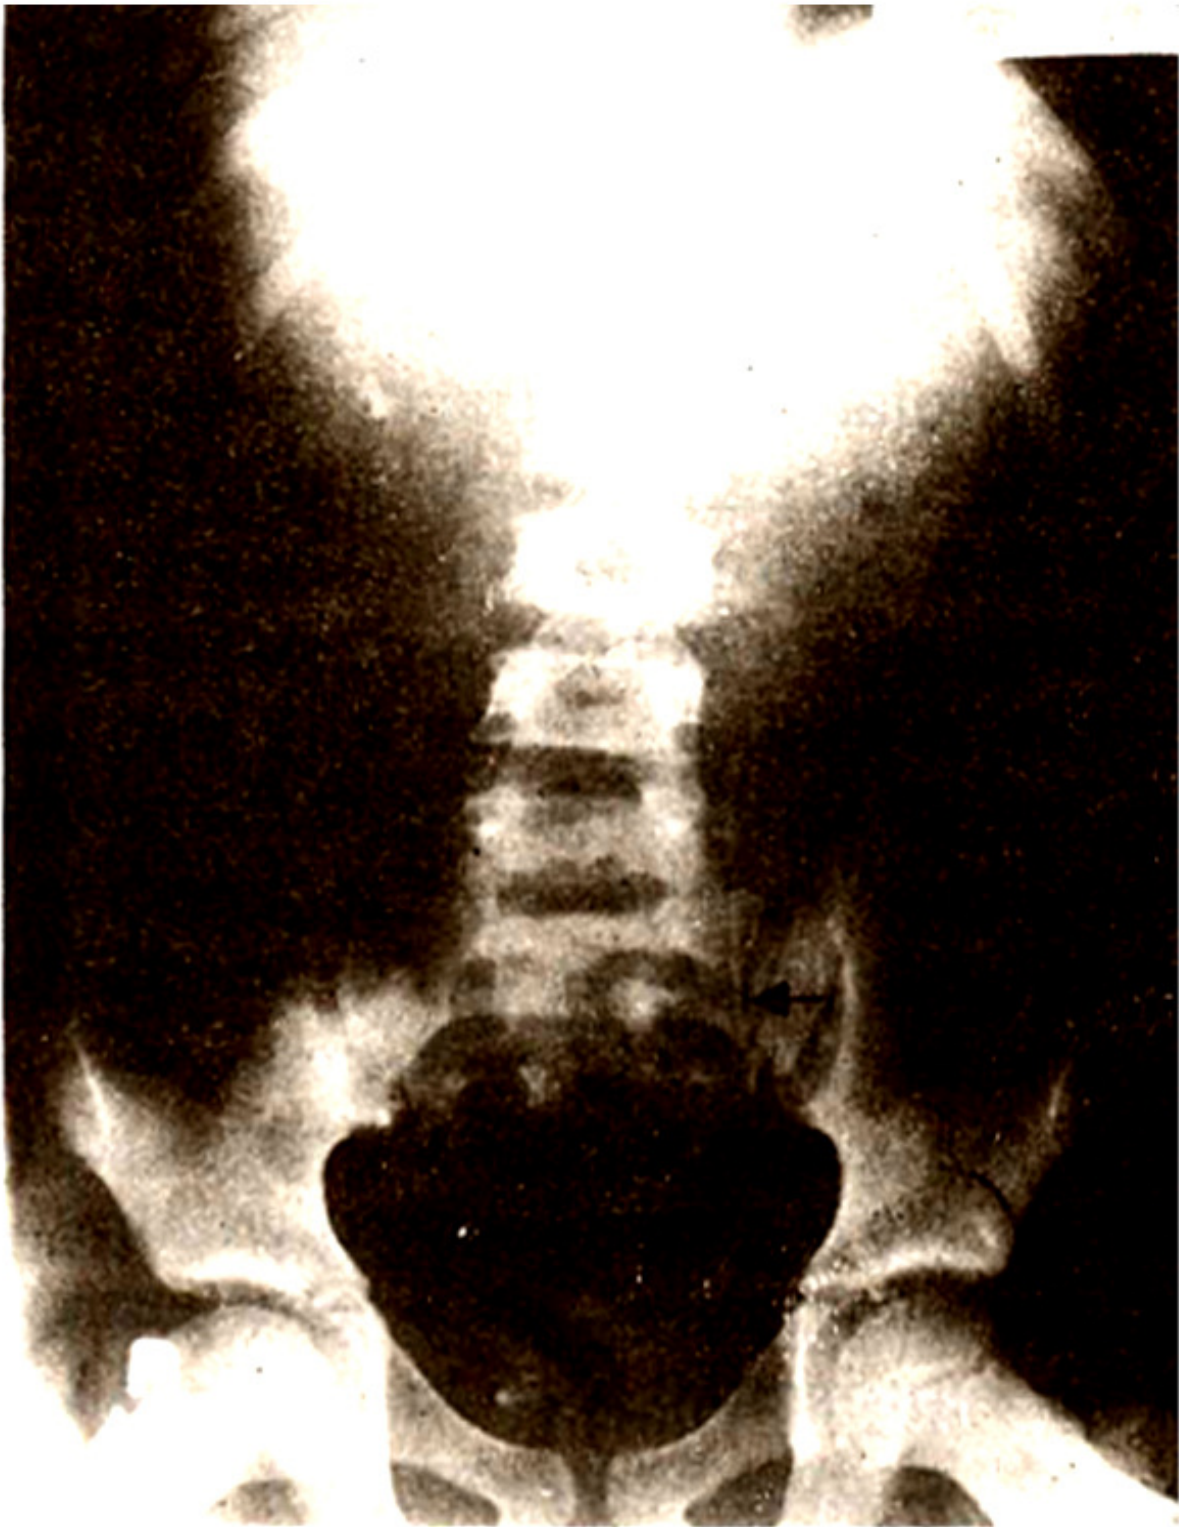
Plain X-ray abdomen showing double J Stent in left ureter.
